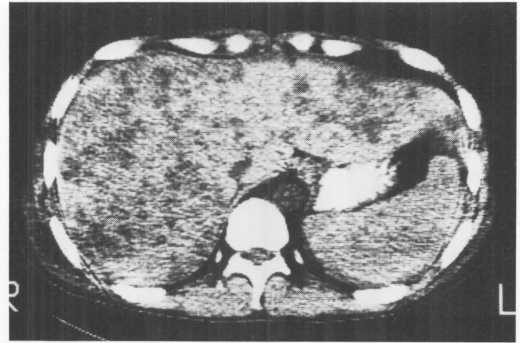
Case 1, male, 20 years of age with ALL. A. Posteroanterior chest radiograph demonstrates pulmonary aspergillosis in the mid lung field. Treatment with an antimycotic drug transformed the consolidation into a characteristic fungus mass with a cavity.
